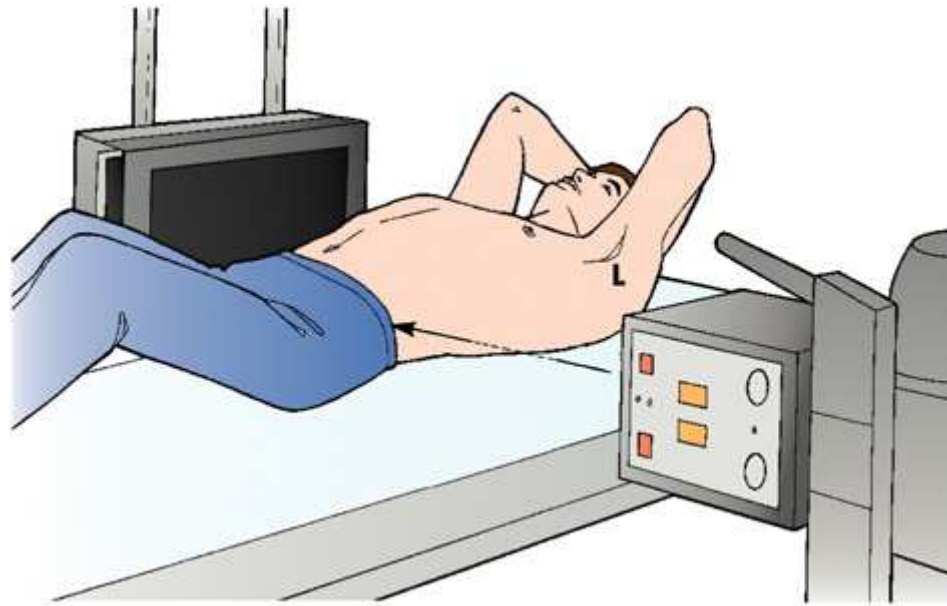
Right dorsal decubitus radiographic position of abdomen results in right lateral projection. Note horizontal orientation of central ray.
